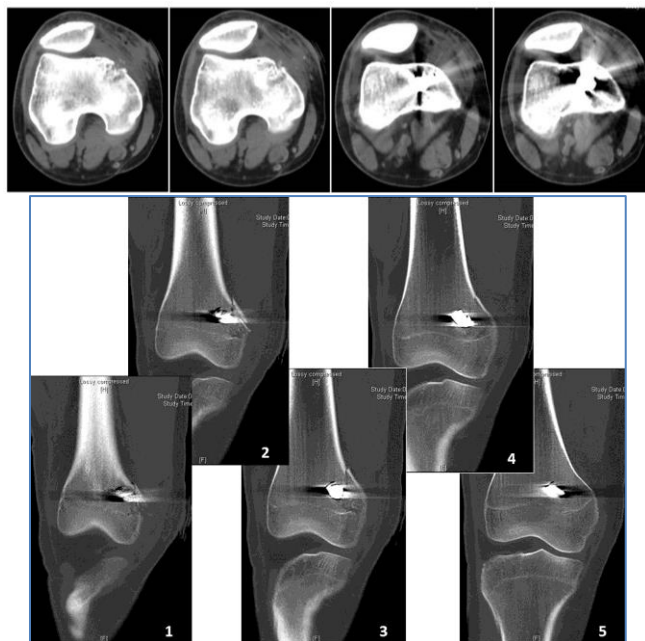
CT scan of right knee
